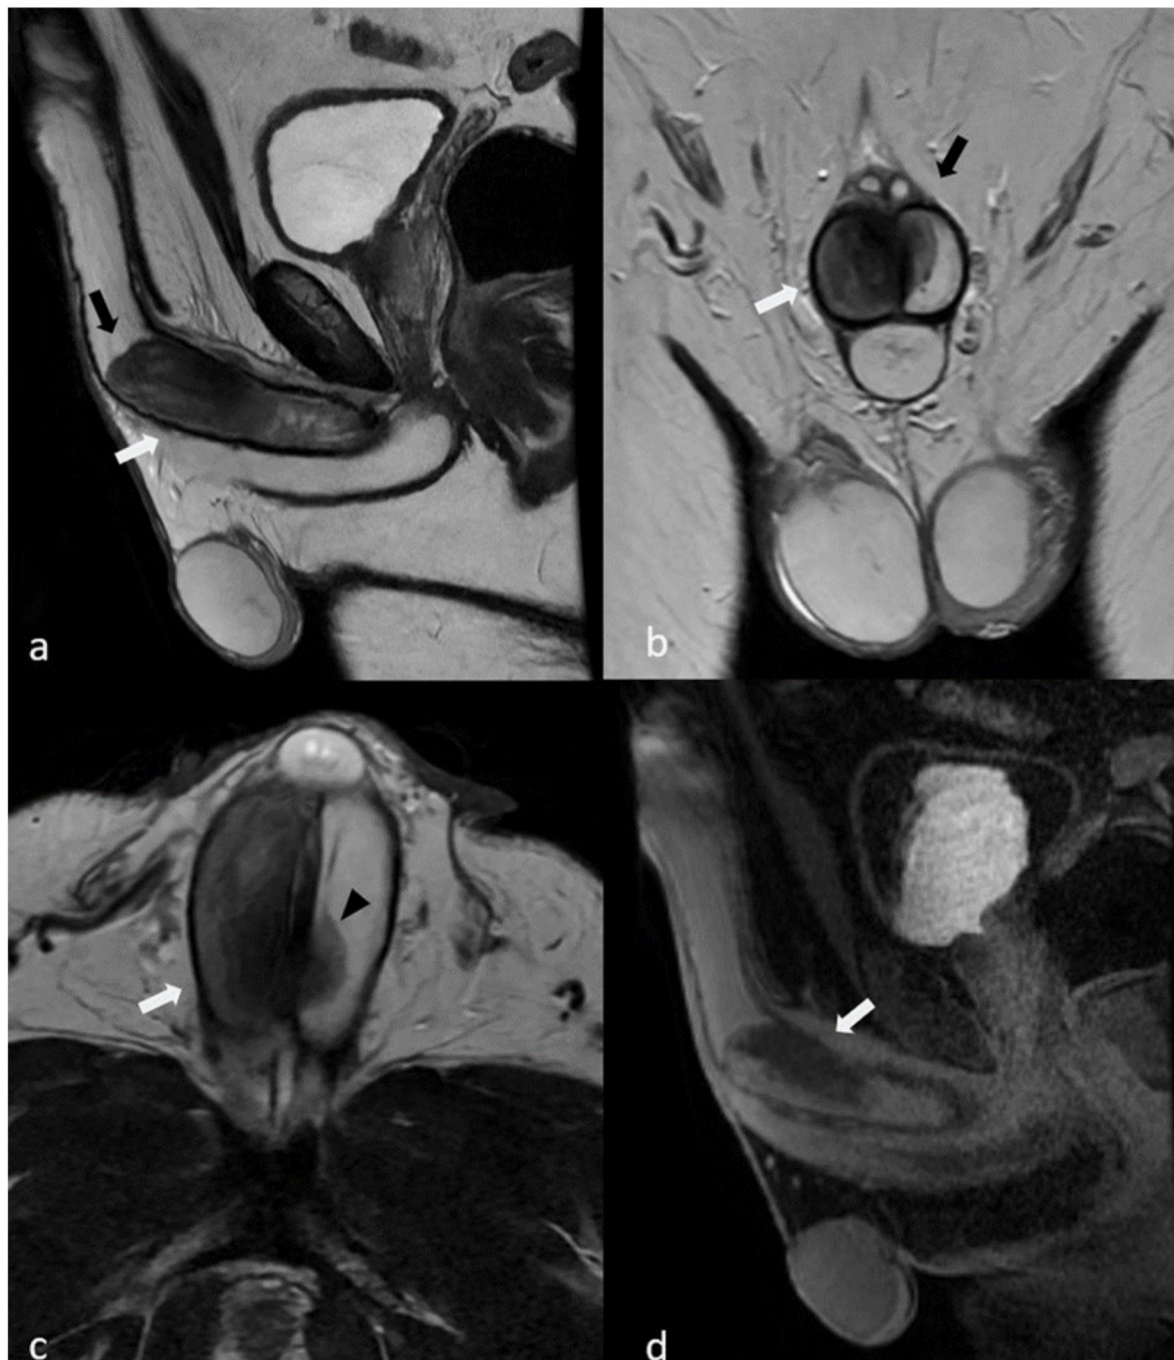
Selected penile magnetic resonance images. Figures a, b and c present sagittal, coronal and axial T2 sequence slices where a hypointense signal is evident in the right corpus cavernosum (white arrow), which has a greater volume compared to the contralateral one and a hypointense linear image in a (black arrow) demonstrating a transverse septum. The left corpus cavernosum presents a hypointense area on T2 sequence suggestive of focal thrombotic involvement (black arrowhead). The image in d shows a sagittal cut of T1 sequence with fat saturation and contrast, showing absence of impregnation with intravenous contrast (white arrow) consistent with thrombotic origin.
